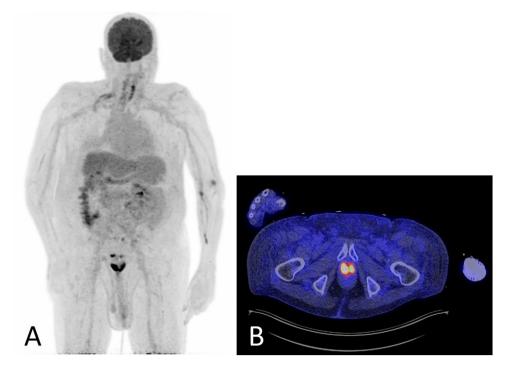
A nonsedated 65-year-old ICU patient presented with septic shock containing Staphylococcus aureus and Klebsiella pneumoniae of unknown origin. The maximum intensity projection of the ¹⁸F-FDG-PET/CT scan (A) shows less brain activity than usual, probably caused by the followed ketogenic diet, and more activity in secondary respiratory muscles. There is slightly elevated liver uptake and renal clearance is less, both due to organ failure. Most pronounced is the ¹⁸F-FDG uptake in the prostate, which is suggestive for prostatitis (B). No other infectious foci could be found. Biograph Vision Quadra (Siemens Healthineers, Erlangen, Germany), axial field-of-view 106 cm, scan-time of 3 minutes in one bed position.
